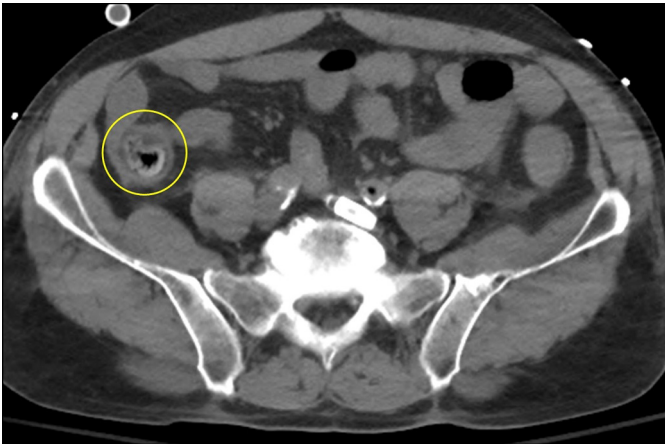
Computed tomography scan (coronal view) revealing pancolitis, most severe around the cecum (circle).
